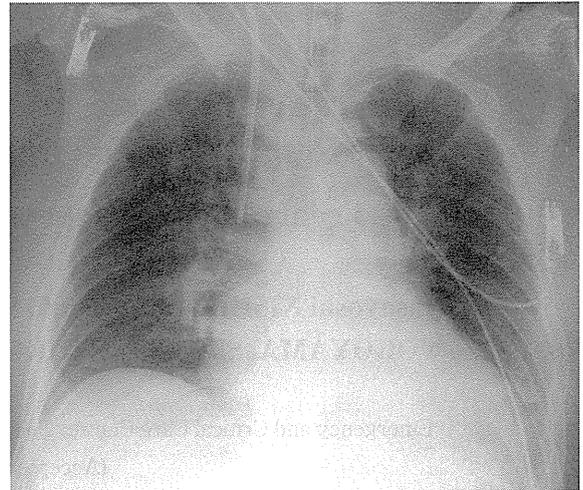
Chest X-ray film on the sixth day
